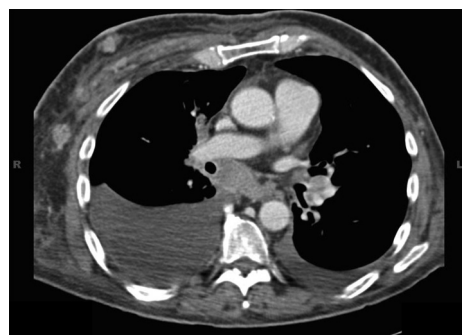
Computed tomography scan of the thorax: malignant pleural effusion, involvement of the pectoralis major muscle and sternocleidomastoid muscle, and a 1.8- × 1.4-cm subcutaneous nodule in the right subareolar region.
